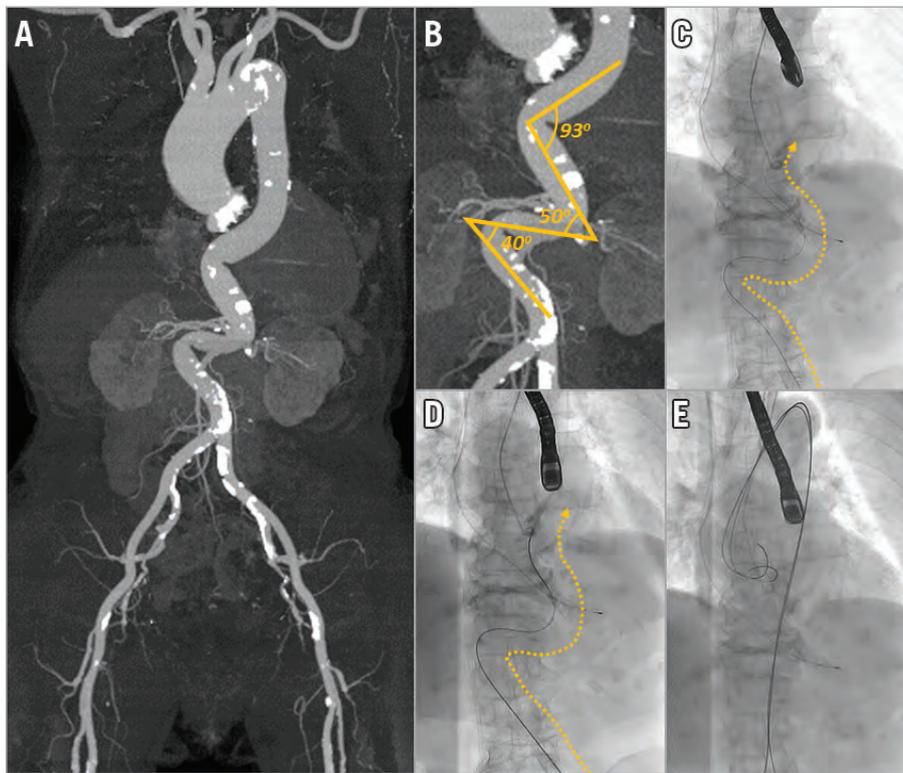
Extremely tortuous abdominal aorta. A) & B) Computed tomography showing extremely tortuous abdominal aorta. C) Radifocus guidewire M with a 4 Fr Judkins right 4.0 catheter from the left femoral artery (dotted arrow). D) Lunderquist wire through the 4 Fr Judkins right 4.0 catheter from the left femoral artery (dotted arrow). E) Buddy wire technique with two Lunderquist wires from the bilateral femoral arteries.
